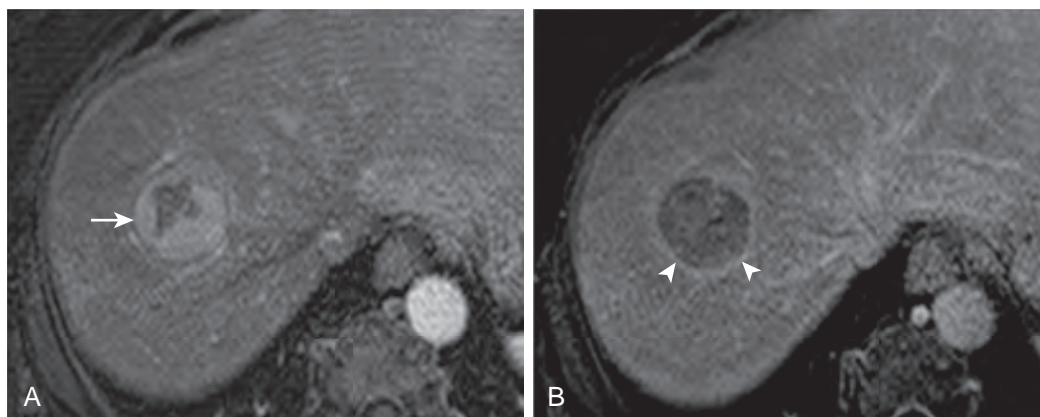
HCC identified during pretransplantation evaluation. A. Arterial phase of contrast-enhanced MRI shows a hyperenhancing right hepatic lesion (arrow). B. A delayed image shows washout of contrast material from the tumor. A peripheral pseudocapsule is noted (arrowheads).
